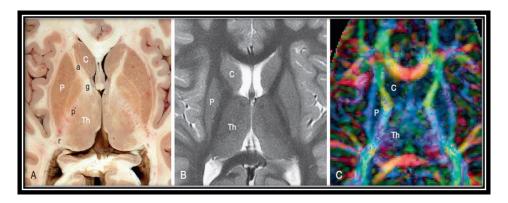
Internal capsule different parts. (A) Axial anatomic section and (B) T2WI MRI: The anterior limb (a), genu (g), posterior limb (p) and retrolenticular (r) portion of the internal capsule course between the caudate nucleus (C) and thalamus (Th) medially. P, putamen. (C) DTI color map the blue coloration in the posterior limb indicates that the fibers are oriented vertically, while the fibers in the anterior limb, genu and retrolenticular portion of the internal capsule course obliquely (*Quoted from Naidich et al.*, 2013).
